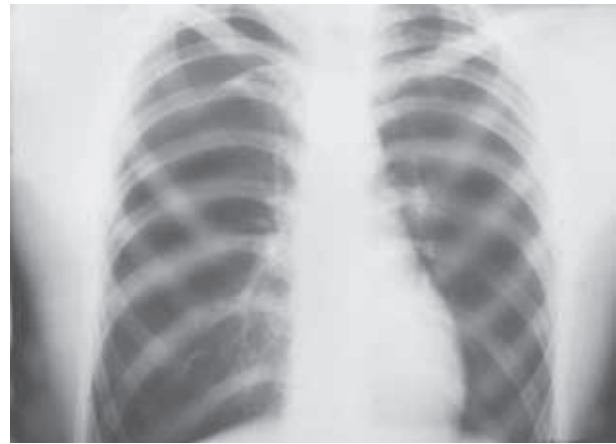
Chest X-ray or direct projection: right pneumothorax
